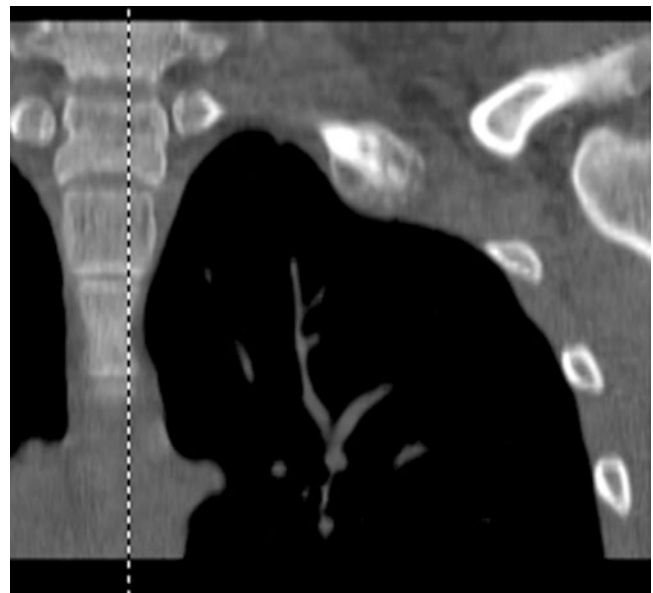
CT scan demonstrating left first rib stress fracture in a male collegiate gymnast with abundant callus formation
